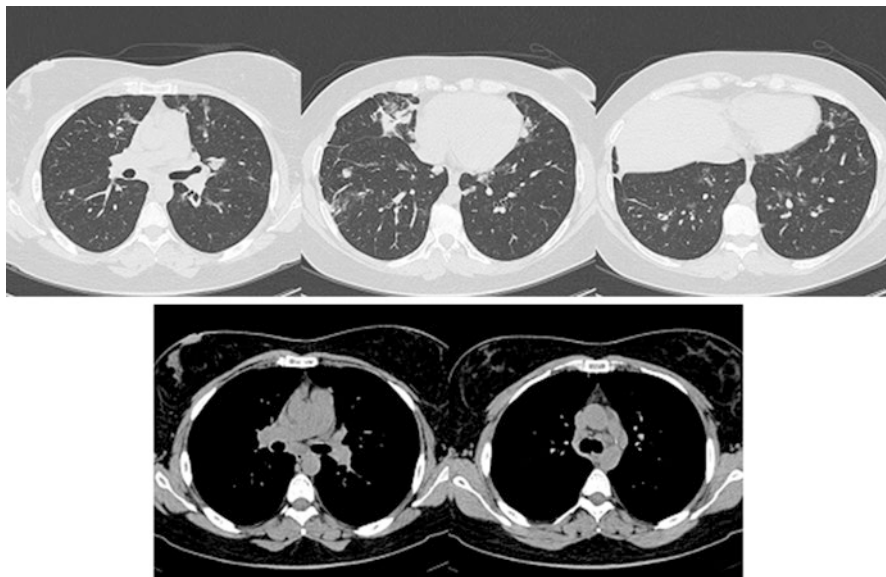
Chest CT of a female patient affected by CVID showing granulomatous involvement of the lung (GLILD). Nodular and ground-glass opacities are seen in lung parenchyma, while lymphadenopathies are present in the mediastinum (personal archive). Courtesy of Dr Vivarelli
